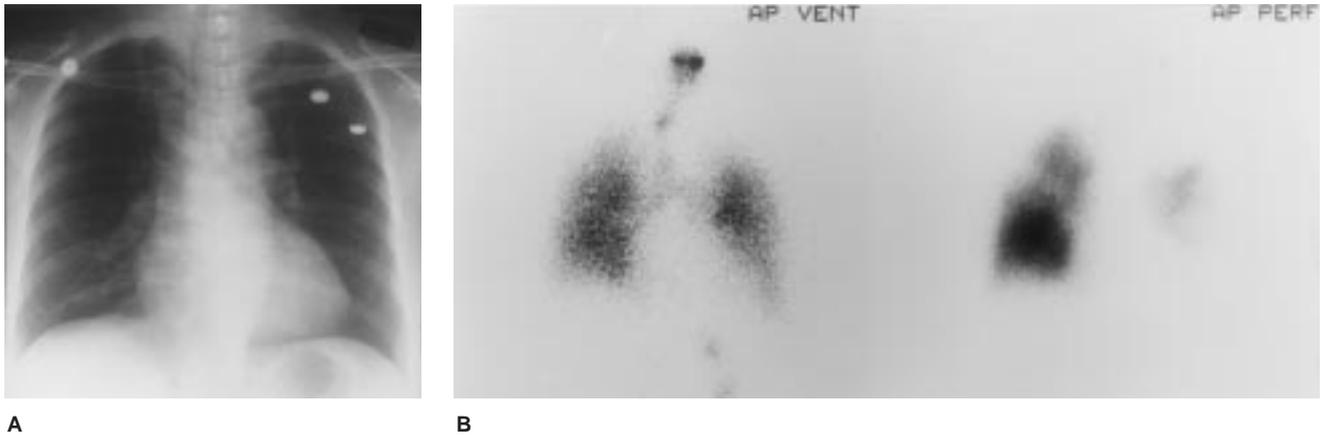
A, Normal chest radiograph of a patient noted to be hypoxic postoperatively. B, Ventilation-perfusion study of the same patient. Perfusion scan (right) reveals multiple perfusion defects, including wedge-shaped defects in the right upper lobe and almost the entire left lung field. Ventilation scan (left) appears normal.
